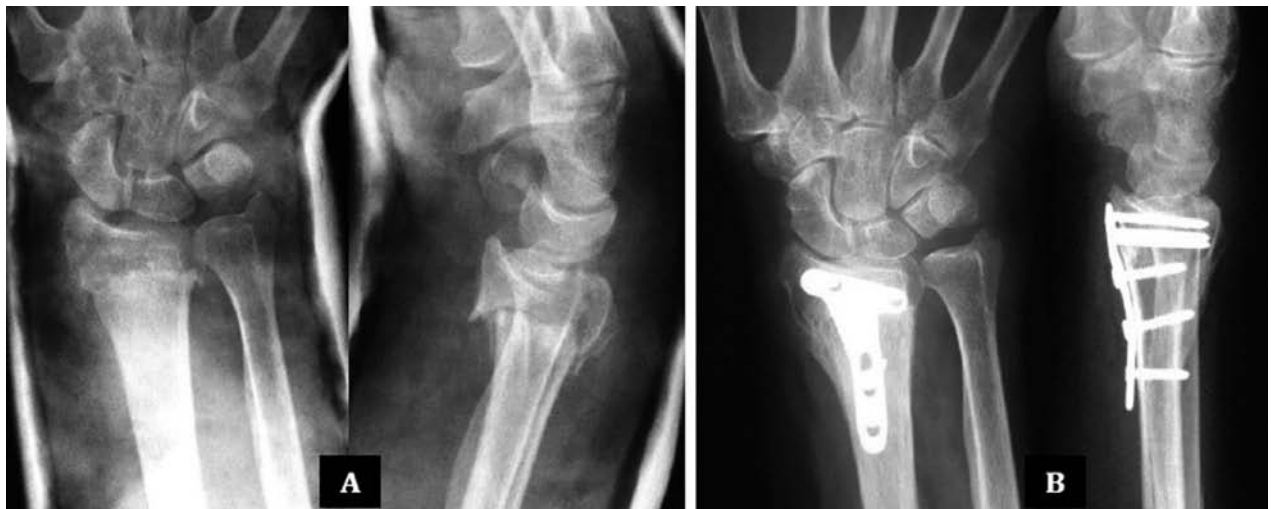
A: 56 years old woman with articular fracture of the distal radio. B: radiographic check 6 months after surgery: synthesis with angular stability plate Synthes LCP
